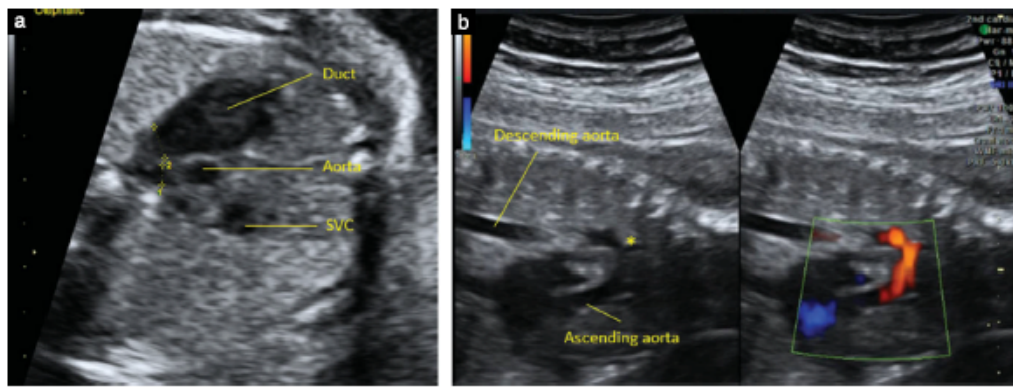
Appearance in a fetus with coarctation of the aorta: (a) three vessels and trachea view, showing marked disproportion of the great arteries; (b) two-dimensional ultrasound and power Doppler sagittal view of aortic arch, showing hypoplasia of the transverse arch with a posterior shelf at the isthmus (*). SVC, superior vena cava. Calipers in (a) show measurement of aortic isthmus and ductal arch diameters.
